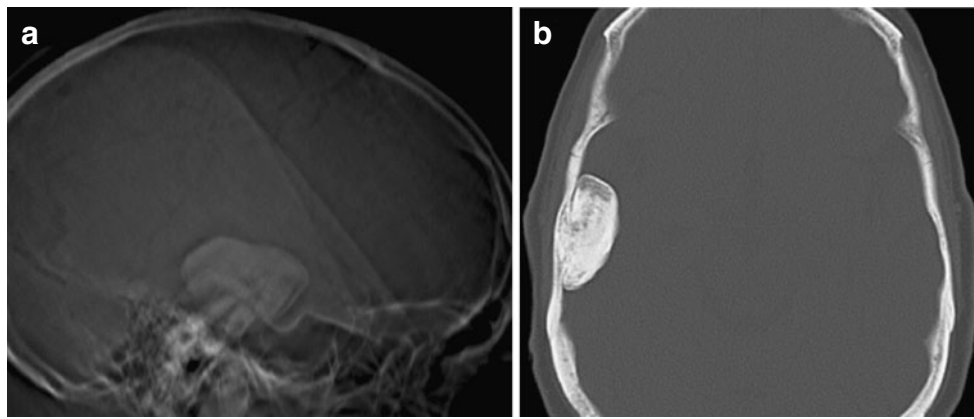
Osteoma of the inner table in a 68-year-old woman. a Lateral skull radiograph revealing a well-defined dense lesion of the temporal bone. b CT scan with bone algorithm showing an ossified mushroom-like tumor with sharp borders attached by a bony stalk to the inner table
